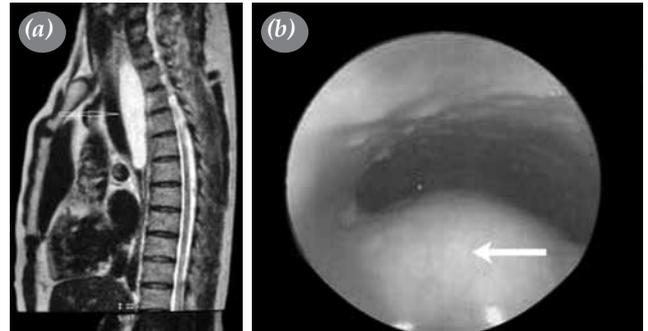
(a) Magnetic resonance imaging of the thorax showed a submucosal elongated lipoma (arrow) with luminal narrowing in the upper third of the thoracic esophagus. (b) An upper gastrointestinal endoscopy showed a large mass covered by a normal mucosa arising from the posterior wall (arrow = lipoma of the esophagus). (c) Macroscopic findings of the esophageal tumor revealed that it was yellowish in color and had an adipose tissue-like appearance.
